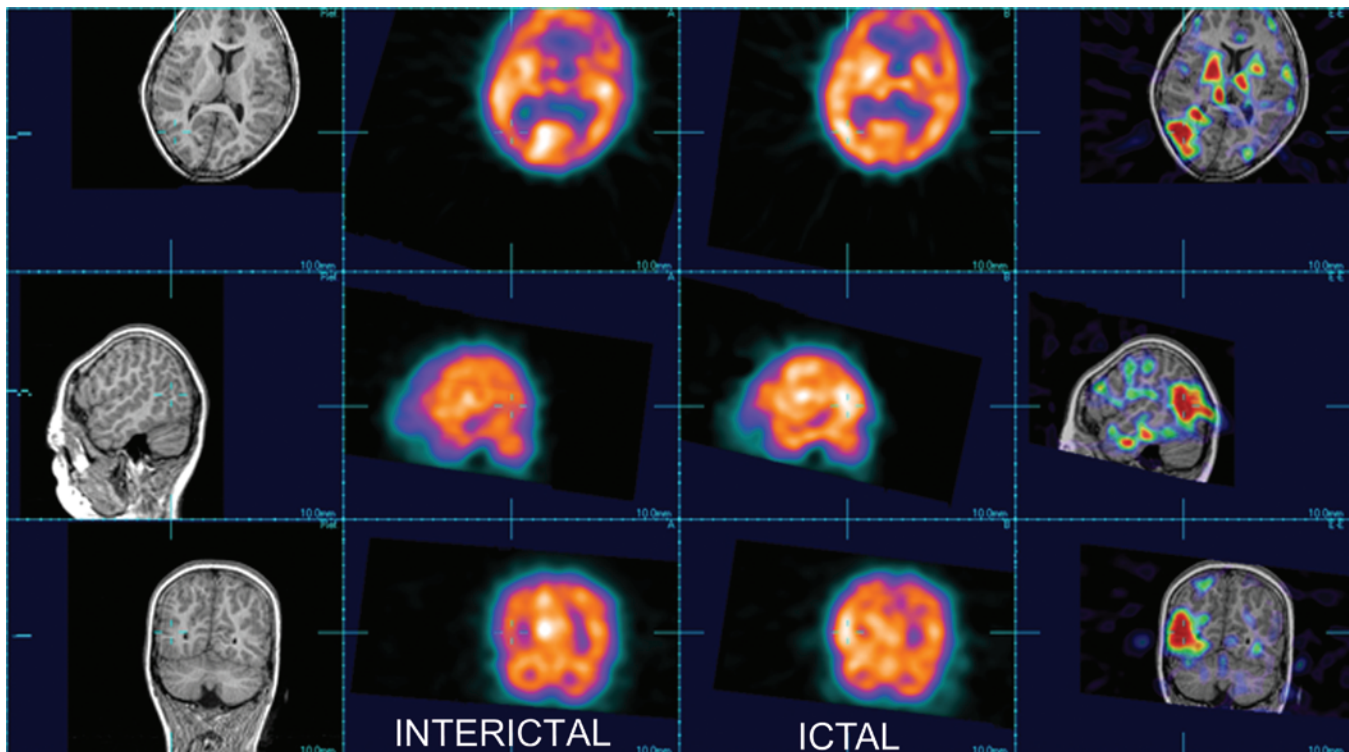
Results from interictal and ictal SPECT demonstrating the region of hyperperfusion in the right occipital lobe (upper row axial, center row sagittal, lower row coronal). The ictal SPECT has been coregistered and fused (gray scale) with the T1-weighted MRI (first column) in the final column.
